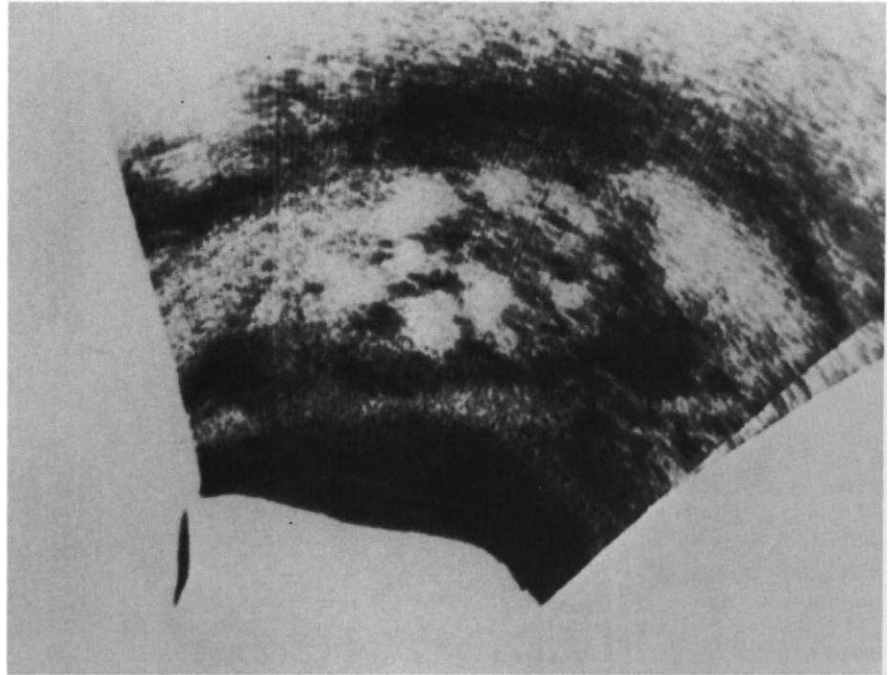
Ultrasonogram demonstrating enlargement of the kidney and the areas of sonolucency caused by the renal cysts.
